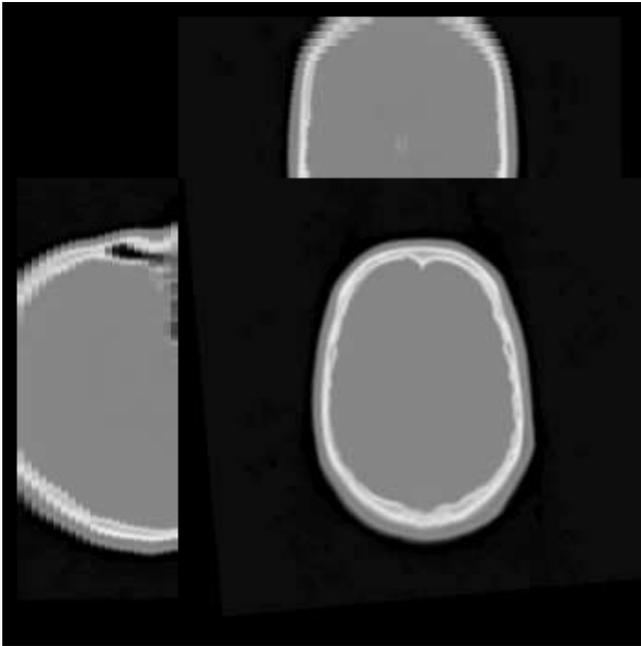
The three central slices of the CT data used in the MR-CT experiments.
